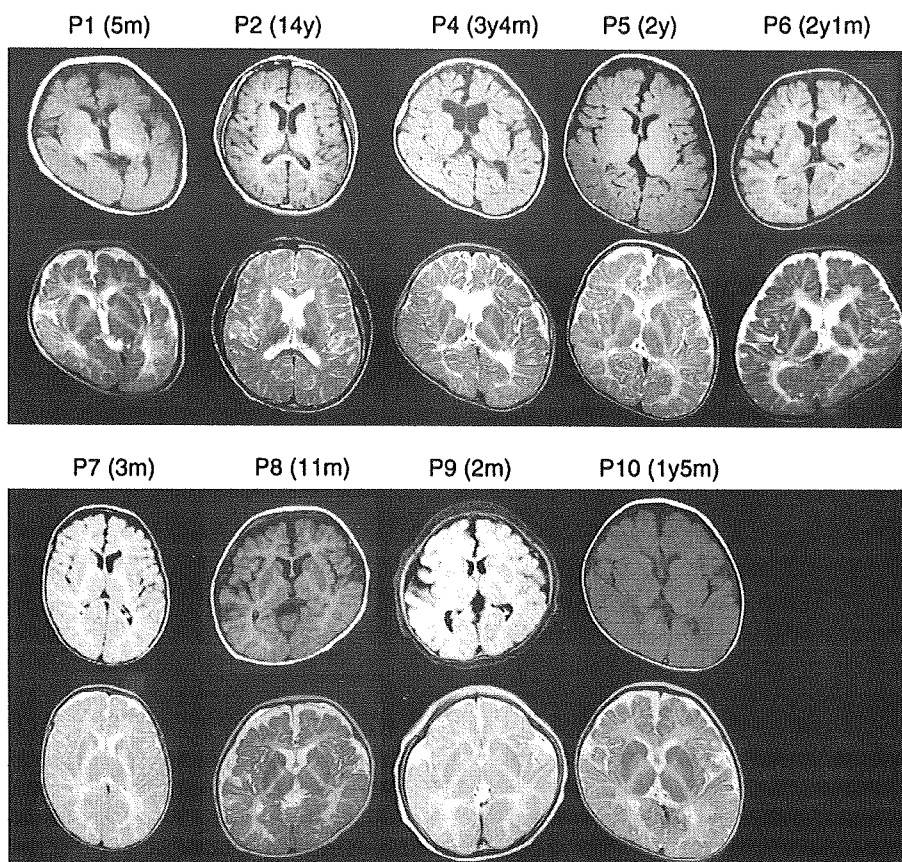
Brain MRIs of nine patients analyzed in this study. Axial T1- and T2-weighted images are in the top and bottom rows, respectively. Ages at the time of examination are shown in brackets. y, years; m, months.
